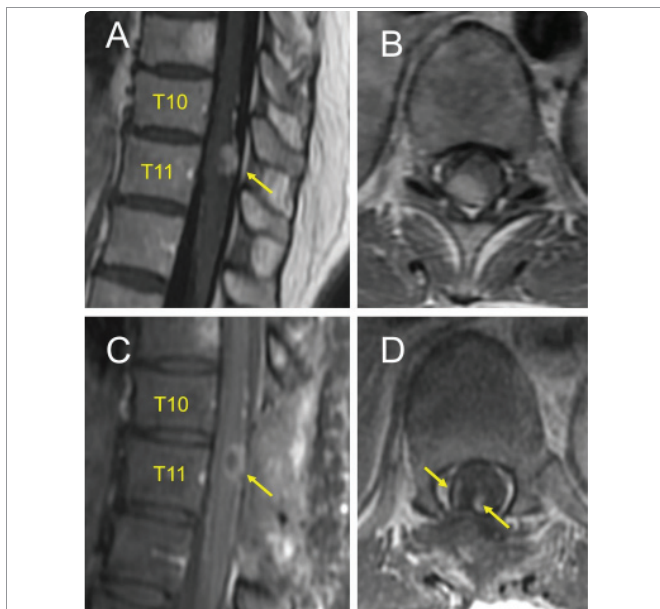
Sagittal and axial MRI scans of IDIM PSM taken pre-operatively (1A & 1B) and post-operatively (1C & 1D). A questionable pial enhancement vs an engorged blood vessel is seen (1A & 1C) extending above and below the lesion. Residual contrast enhancing tumor is demarcated by yellow arrows (1D).
